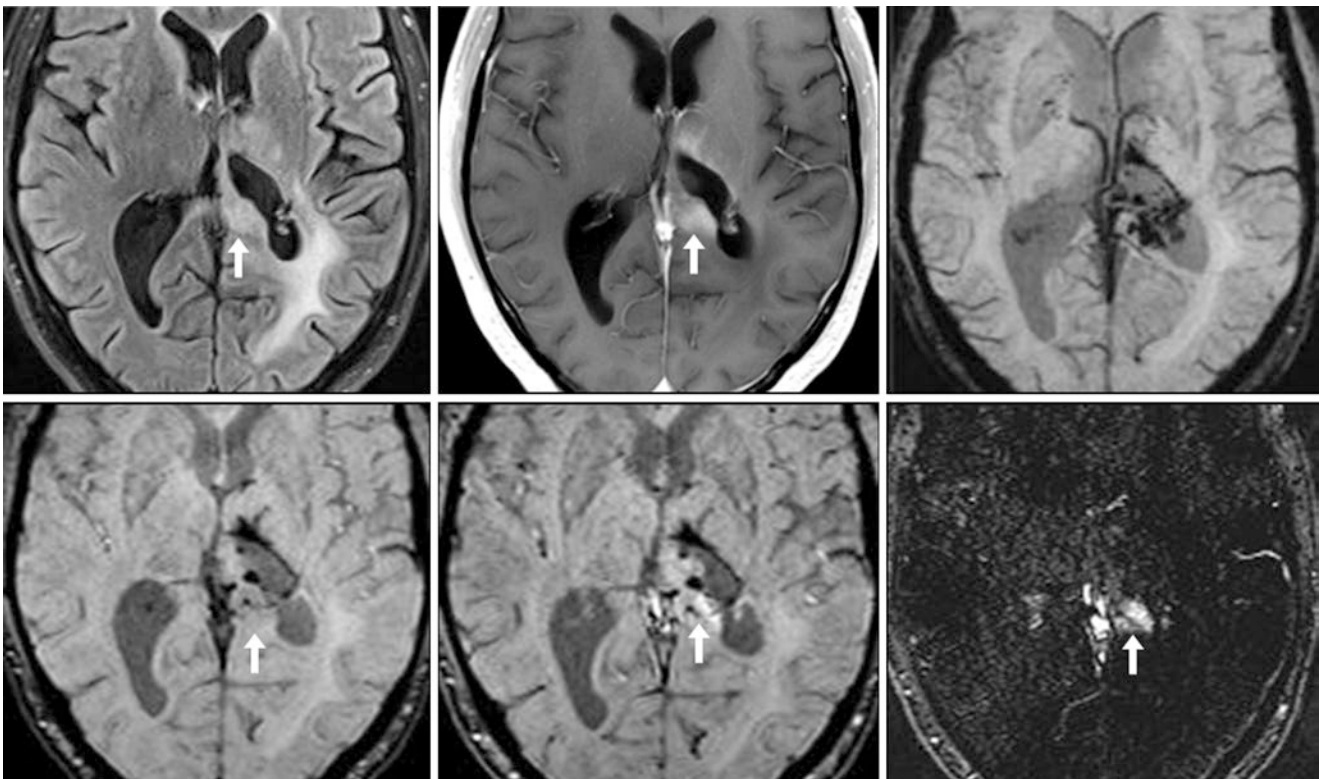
SWI subtraction to detect recurrent tumor. A 48 year old with a previous astrocytoma had enlarging nodularity at the margin of a prior resection (*arrows*) on FLAIR (*top left*), with new enhancement on postcontrast T1WI (*top middle*). On 16-mm-thick pre-contrast SWI (*top right*), hemosiderin was seen around the resection site, also shown on
